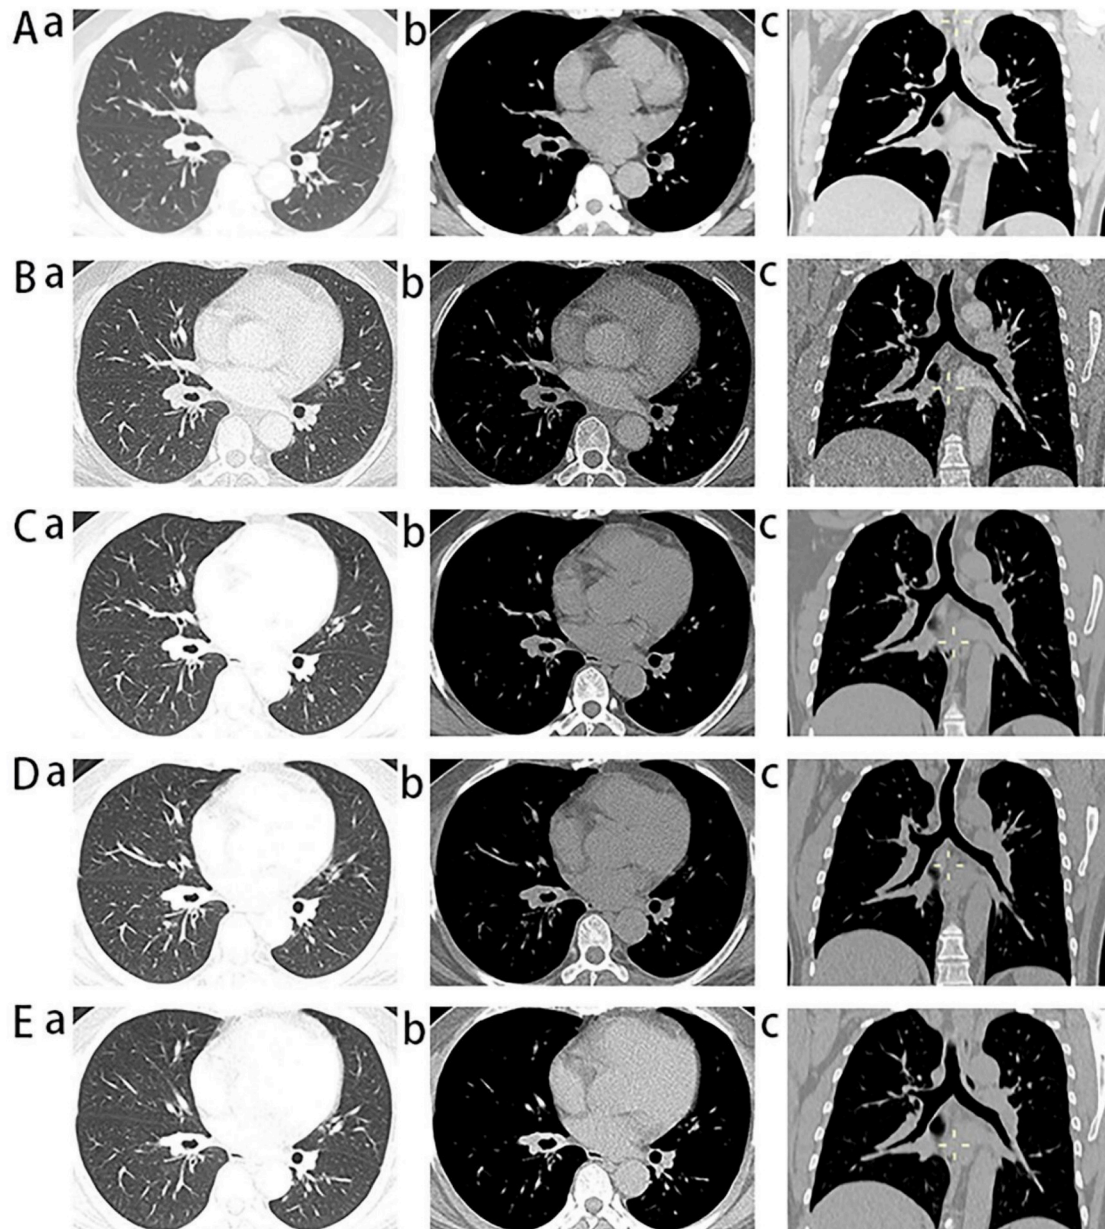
Repeated thoracic computed tomography respectively after 3, 6, 9, 12 and 14 months of treatment, showing disappearance of the previous lesion in the basal segment bronchi of right lower lobe. A: CT scan after 3 month. B: CT scan after 6 months. C: CT scan after 9 months. D: CT scan after 12 months. E: CT scan after 14 months. a: Parenchymal window. b: Mediastinal window. c: Coronal section.
